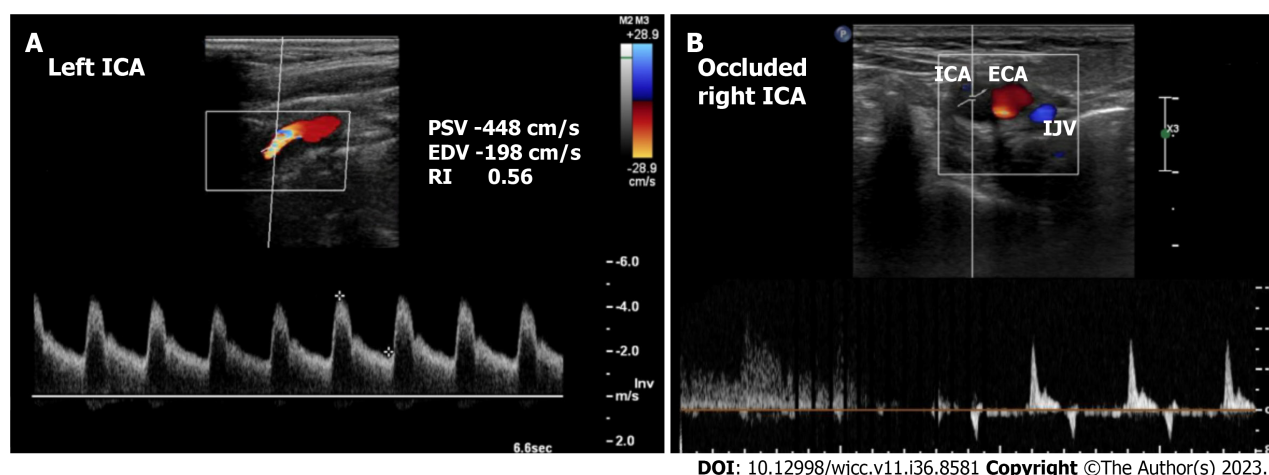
Preoperative carotid ultrasound duplex in case 1. A: Left internal carotid artery stenosis of > 90%; B: Totally occluded right interval carotid artery. ECA: External carotid artery; EDV: End-diastolic velocity; IJV: Internal jugular vein; PSV: Peak systolic velocity; RI: Resistance index; ICA: Internal carotid artery.
